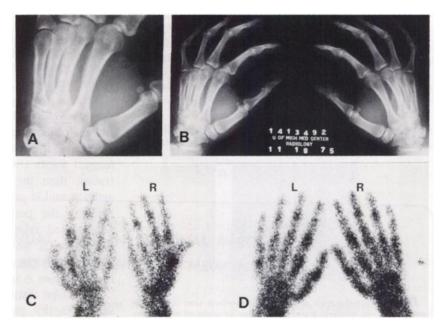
Radiographs (A,B) and scintigrams (C,D) of hands and wrists. Numerous radiographically normal areas show increased uptake. Note striking tracer uptake in several middle phalanges.
